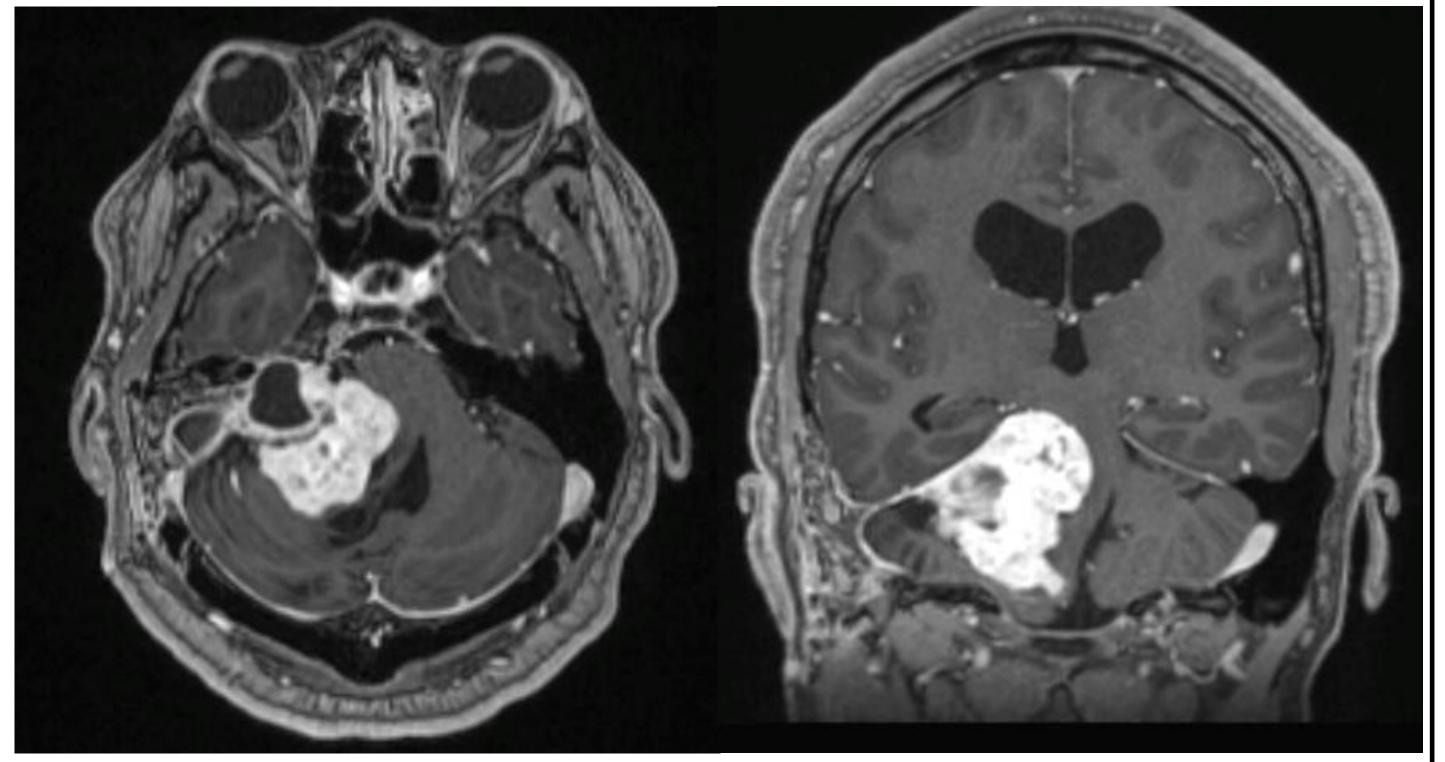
T1-weighted post-contrast IR-SPGR MRI showing axial (A) and coronal (B) images of a large vestibular schwannoma with brainstem compression in a 32-year-old male prior to initial treatment.
